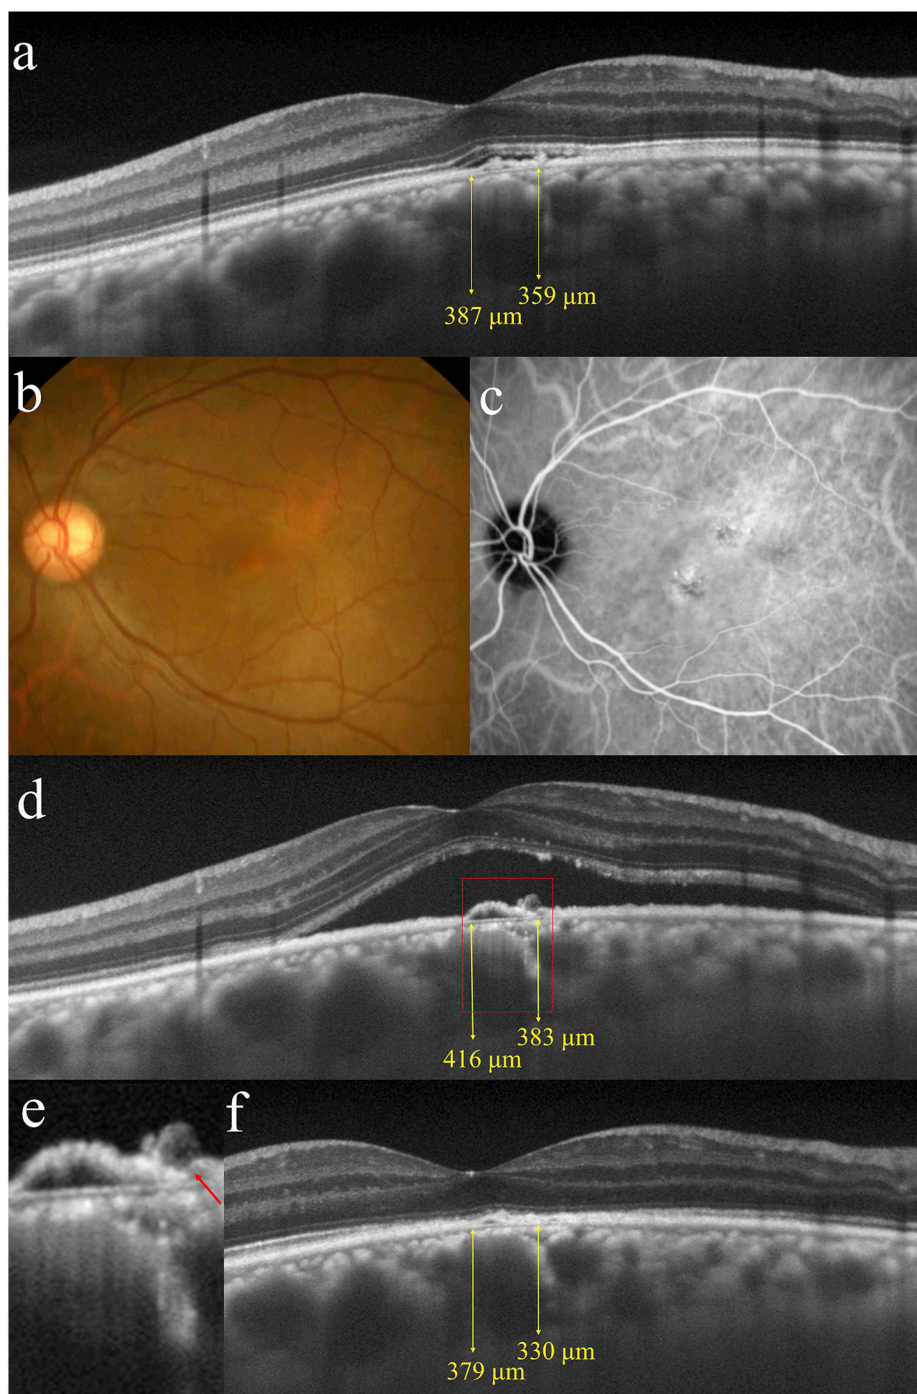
Photographs of the left eye at improvement of PPE (a) and during the onset (b–e) and regression (f) of central serous chorioretinopathy (CSC) in Case 1. a, Seven months later, EDI-OCT showed recovery of the ellipsoid zone corresponding to the lesion. However, dome-shaped hyper-reflectivities of the RPE and a hypo-reflectivity between the interdigitation zone and the RPE appeared. CCT and CT at the lesion site decreased to 387 and 359 μm , respectively. b–e, Photographs 19 months after the initial visit. Macular SRD appeared (b). On ICGA 10 min post-dye injection, the extent of choroidal vascular hyperpermeability increased compared with that at the initial visit (c). EDI-OCT revealed macular SRD with enlargement of RPE detachment. CCT and CT at the lesion site increased to 416 and 383 μm , respectively (d). e, A magnified view at the fovea of (d). An apparent hole of the RPE (arrow) was observed, corresponding to the lesion site of PPE. f, Twenty-five months after the initial visit, SRD spontaneously resolved. CCT and CT at the lesion site decreased to 379 and 330 μm , respectively.
